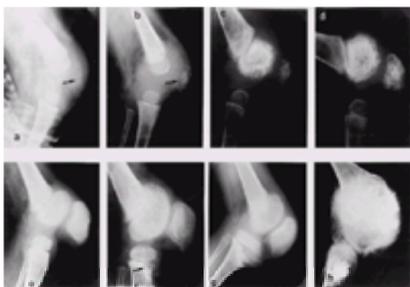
Follow-up of radiographic anomalies in the knee at various ages: (a) 1 year; (b) 1 year and 6 months; (c) 2 years and 6 months; (d) 3 years and 9 months; (e) 5 years; (f) 6 years (arrow: late modification of tibial growth cartilage); (g) 8 years; (h) 33 years (another patient). (Reproduced from [Prieur et al. 1987](#), with permission.)
